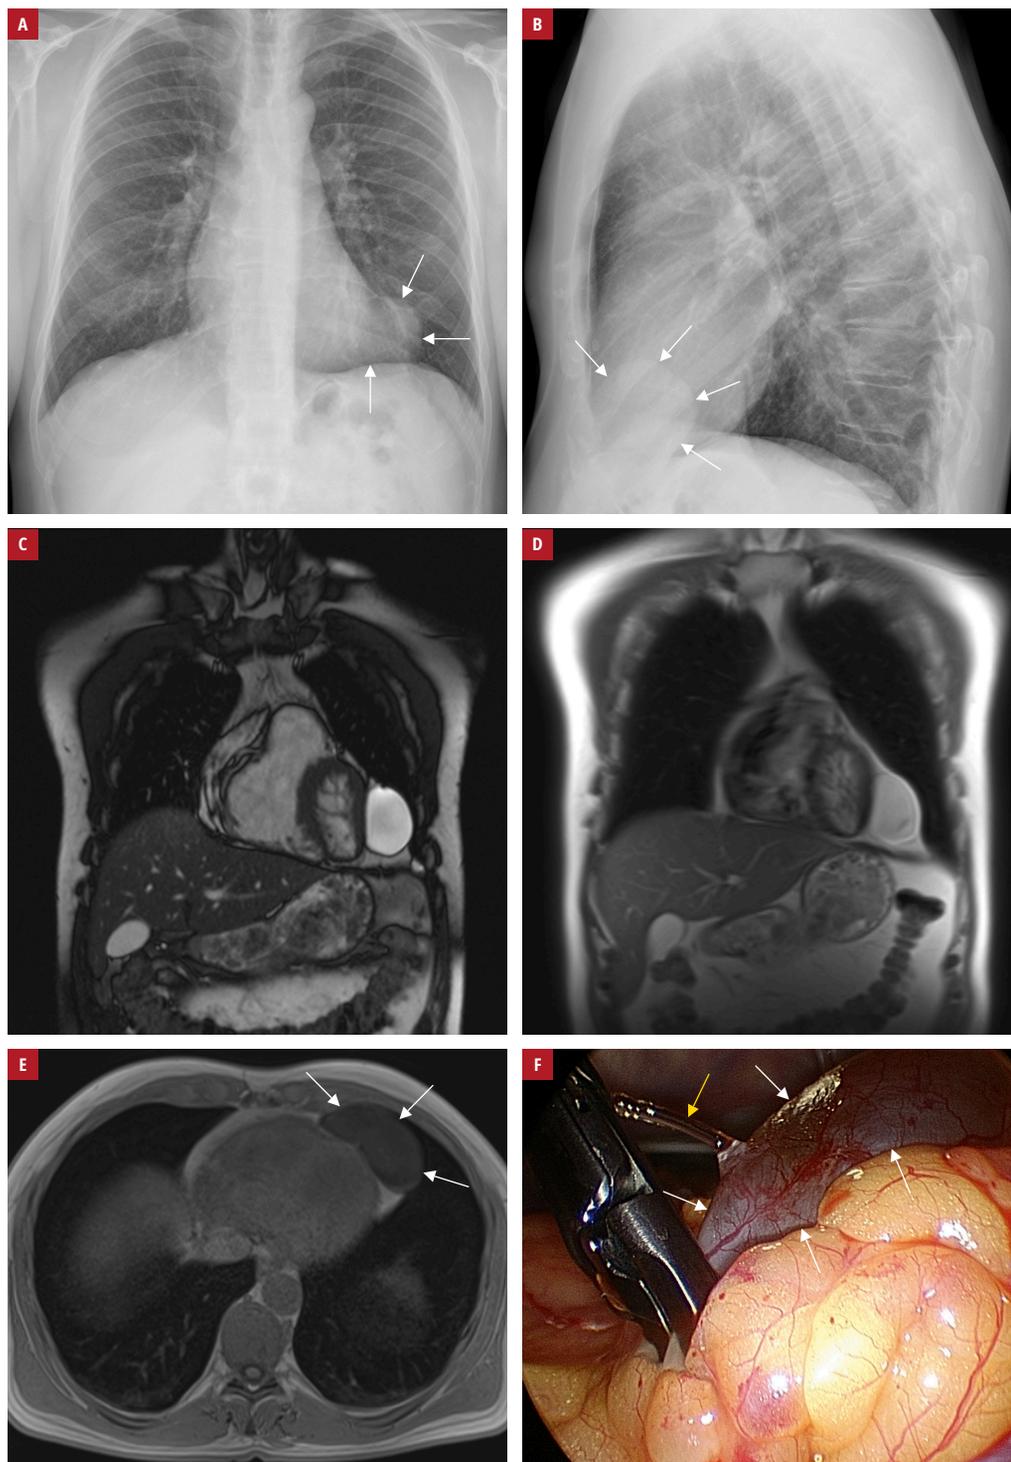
Imaging of a patient with a pericardial cyst: A, B – chest X-ray showing a large, rounded structure at the cardiac apex (arrows); C–E – magnetic resonance imaging demonstrating a thin-walled, homogeneous structure with high signal intensity on steady-state free precession (C) and T2-weighted spin echo (D, coronal plane image) and low signal intensity on T1-weighted spin echo images (E, axial plane image, arrows); F – intraoperative image showing the pericardial cyst (white arrows) and the aqueous fluid (yellow arrow) after puncture
